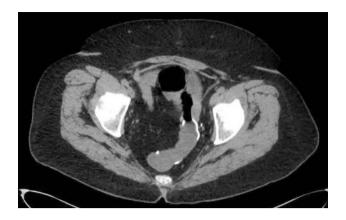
A screenshot of an axial view from a CT scan video showcasing a patient with a Strattice mesh
